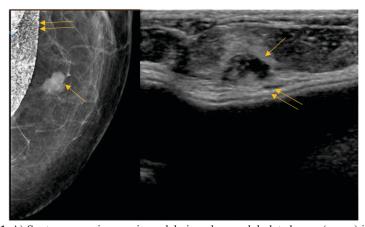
A) Spot compression craniocaudal view shows a lobulated mass (arrow) in the upper inner quadrant adjacent to the silicon implant (double arrow) B) Ultrasound shows a lobulated hypoechoic solid mass (arrow) with irregular borders closely adherent to the implant capsule (double arrow)
